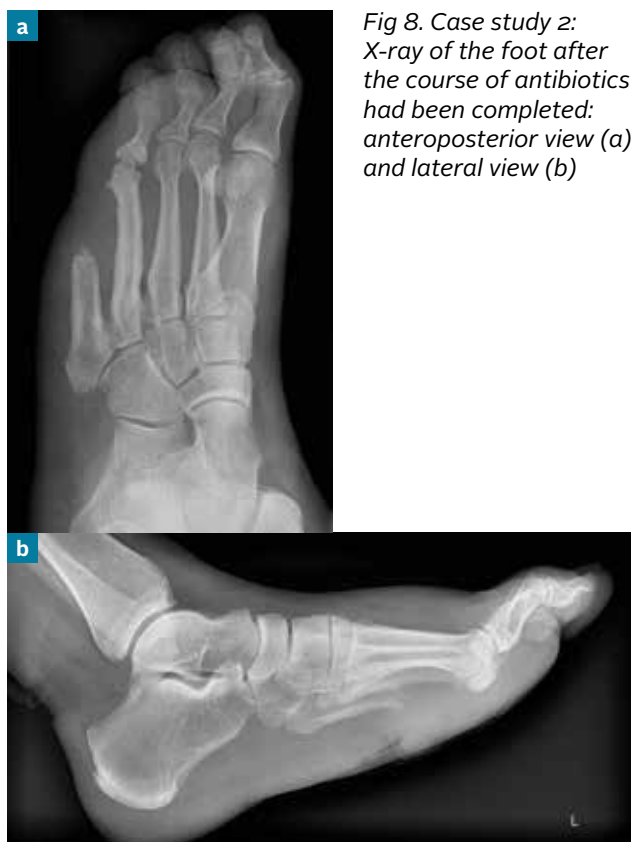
Case study 2: X-ray of the foot after the course of antibiotics had been completed: anteroposterior view (a) and lateral view (b)
